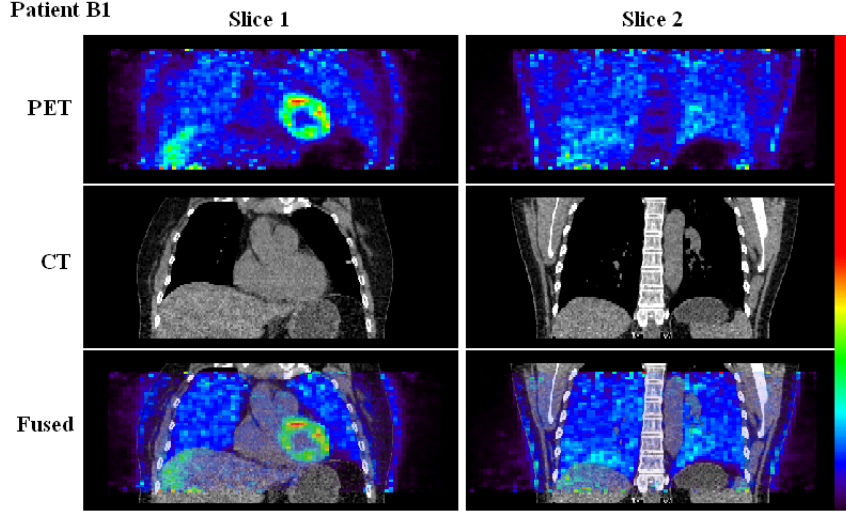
Coronal slices through a single frame of patient B1’s PET-CT dataset, showing the PET, CT and fused PET-CT images for a slice traversing the heart (Slice 1) and a more posterior slice (Slice 2).
